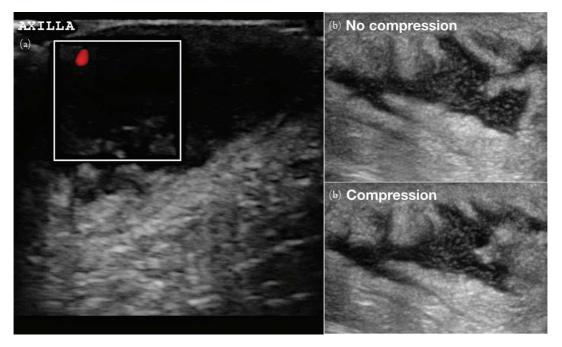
(a) Abscess with peripheral flow. Color Doppler interrogation of the more superficial hypoechoic area indicates minimal color flow (the small area creating signal is near the periphery of the fluid collection). This could be sign of peripheral hyperemia, which can be seen in an abscess. (b) The swirl sign. There is movement of echogenic debris without and with compression. The mobile debris implies purulent fluid that can be drained and may help to distinguish a true abscess versus a phlegmon that cannot be drained.
